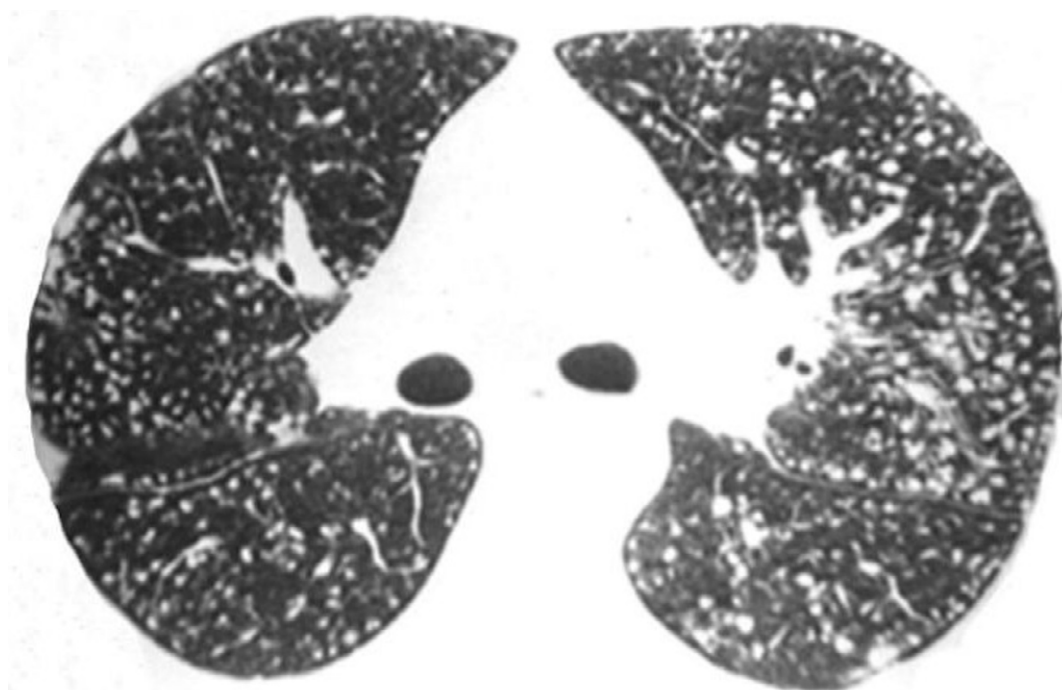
An axial CT scan with lung window settings showing, in the upper lobes, small soft-tissue density nodules that are homogeneously distributed throughout the lungs but not touching the peripheral pleural surfaces or fissures.
